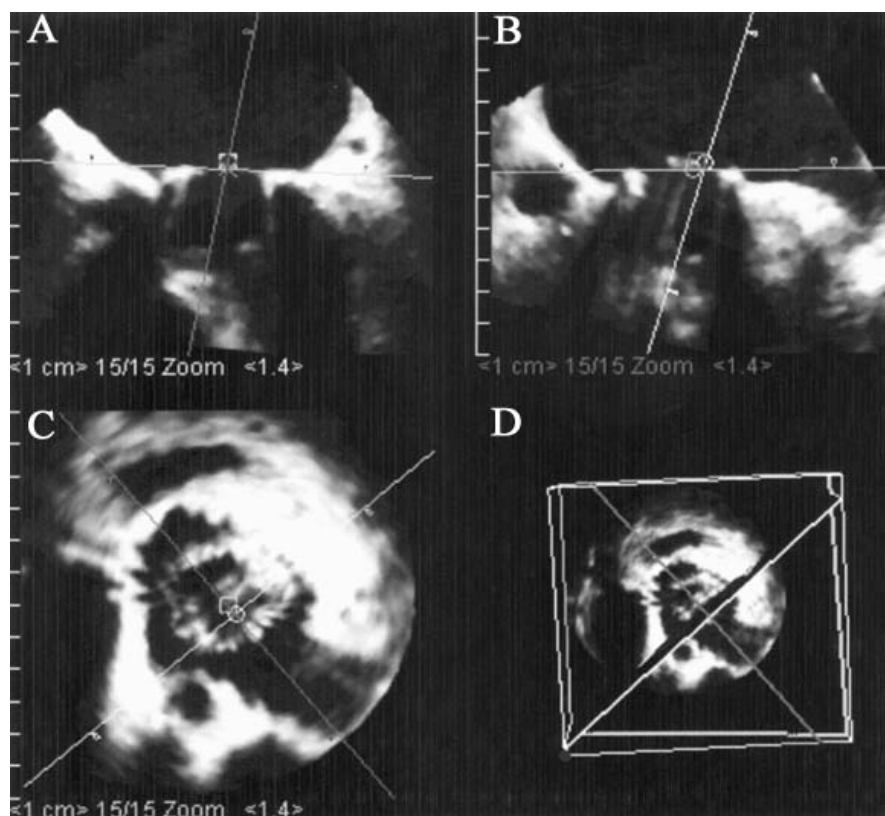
This 4-tile image display window shows a St Jude mitral valve prosthesis with 2 perpendicular longitudinal-axis cut planes (A and B) obtained by anyplane echocardiography. The cut lines were positioned at the level of the inner ring of the mechanical valve at its maximum opening. Thus a true short axis of the valve orifice was derived (C). A reference image (D), in which the cut planes could be positioned freely, was helpful for adjusting, selecting, and observing the optimal cross section.
